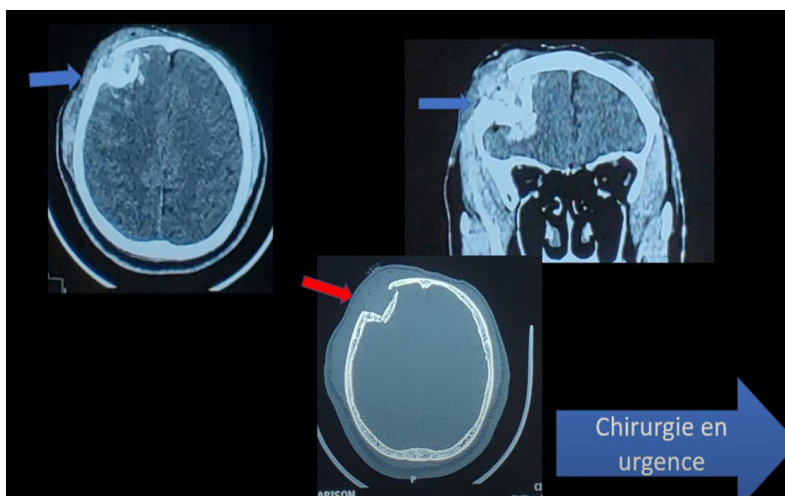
Cranial CT Imaging Showing Comminuted Depressed Frontal Skull Fracture with Intracerebral Bone Fragments, Contusional Hemorrhagic Edema, and Pneumocephalus
